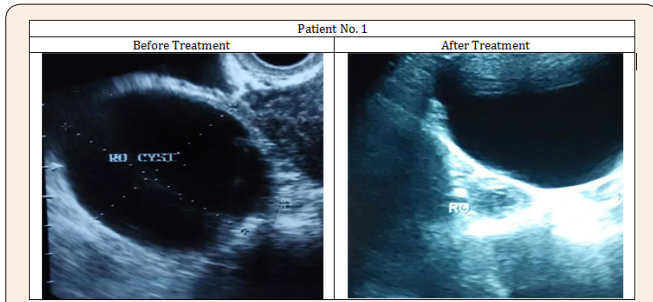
Images of Ultra-sonography of the patient No. 1 showing removal of the cyst from right ovary.
